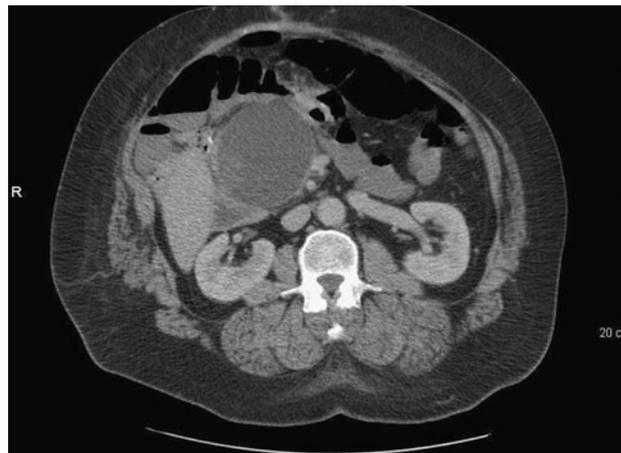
Mature pseudocyst identified on CT abdomen
